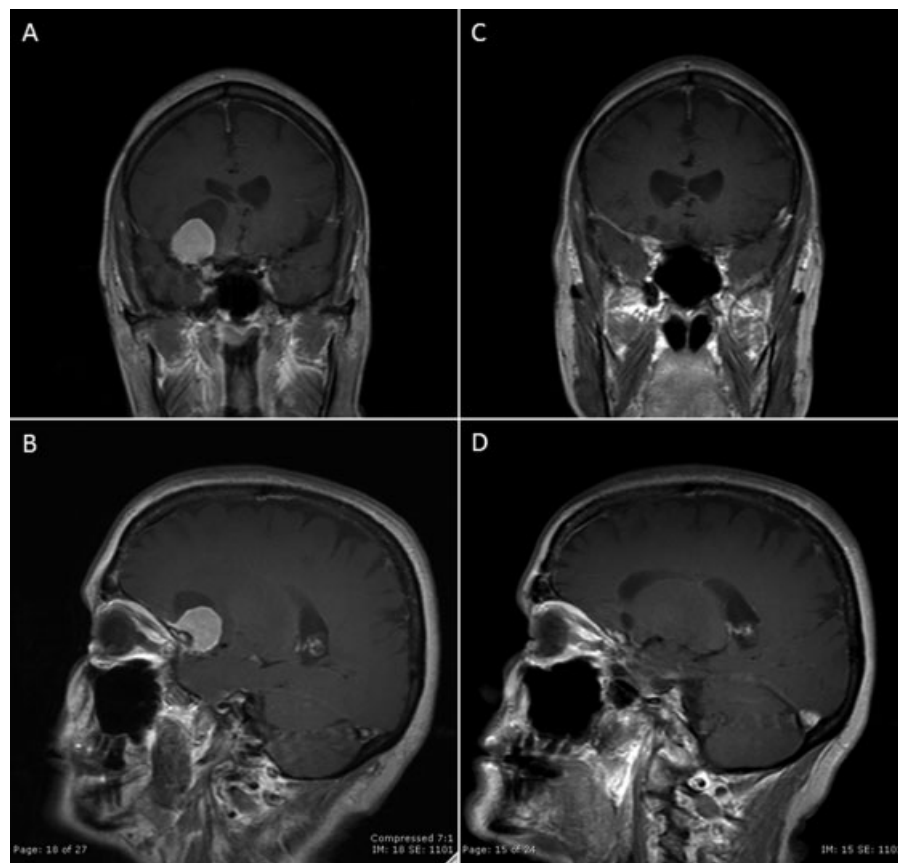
Case 3. (A, B) Preoperative T1-weighted images with gadolinium demonstrating a homogeneously enhancing lesion arising from the right clinoid and medial sphenoid wing with an associated arachnoid cyst. (C, D) Two-year postoperative images demonstrate no evidence of residual or recurrence.
